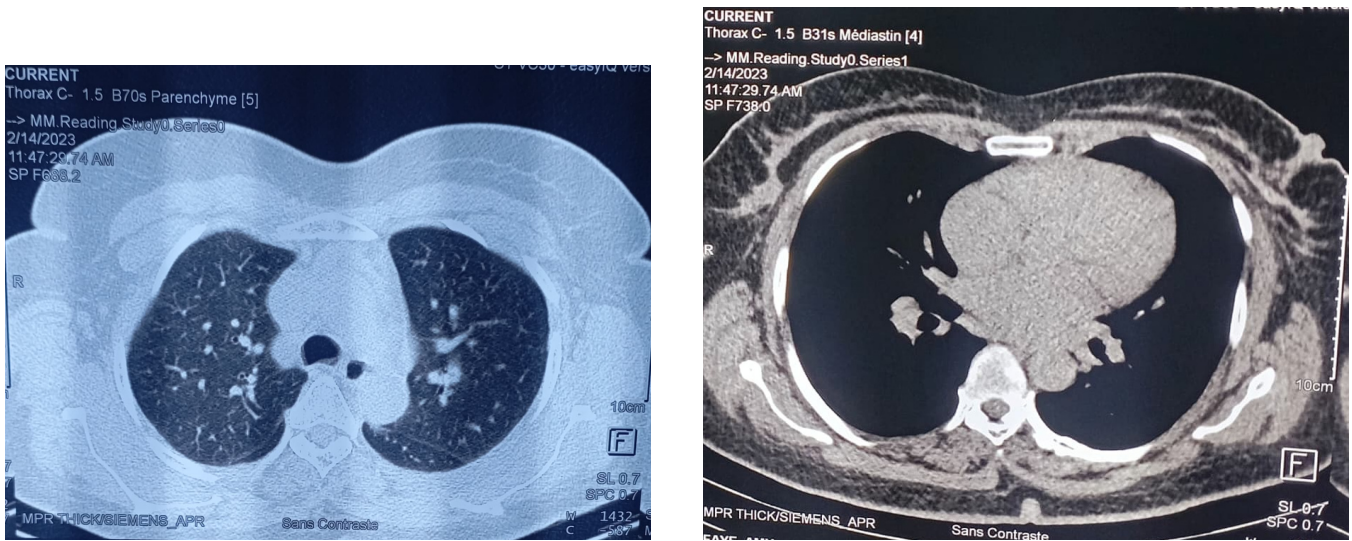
Chest CT angiography showing interstitial lung disease
